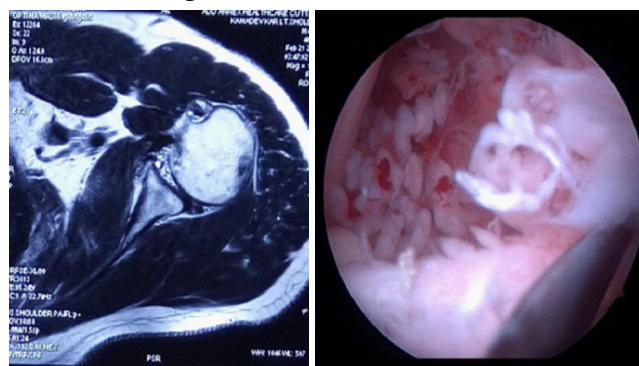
MRI showing multiple calcifications, extensive thickened synovium suggestive of synovial chondromatosis.
